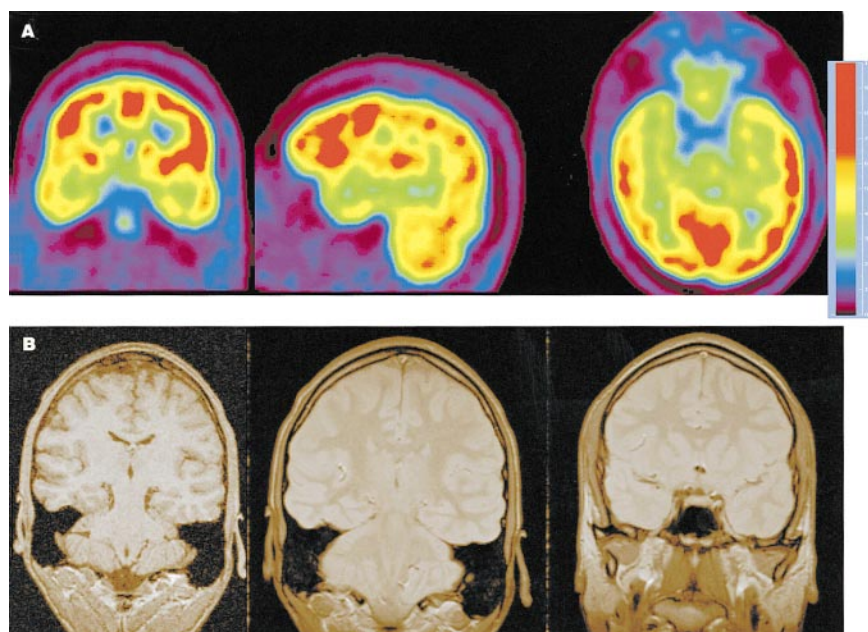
From left to right, coronal, sagittal, and axial FDG PET images (A) from patient with right temporal lobe seizures (on ictal EEG) but normal MRI findings (B). Interpretation of FDG PET images was discordant between the 2 independent reviewers, with 1 initially diagnosing right temporal hypometabolism with low confidence. On joint review, reviewers decided that PET images were nonlocalizing.
